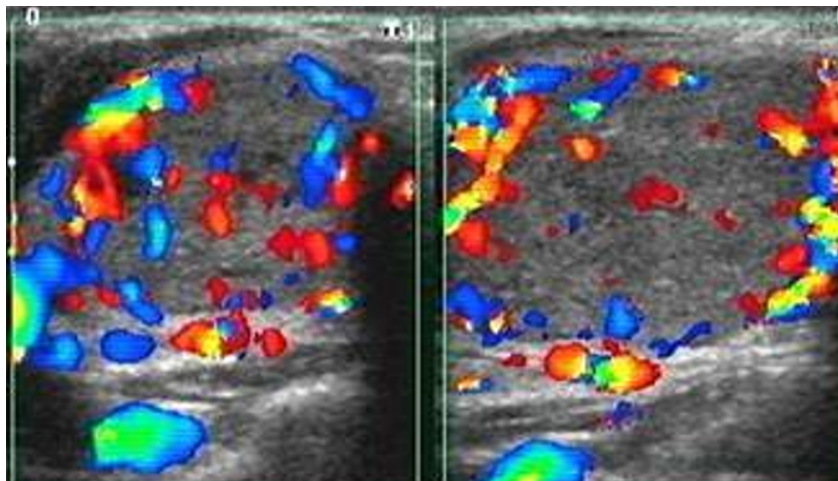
Thyroid nodule with mixed (central + peripheral) intranodular vascularity on Colour Doppler
